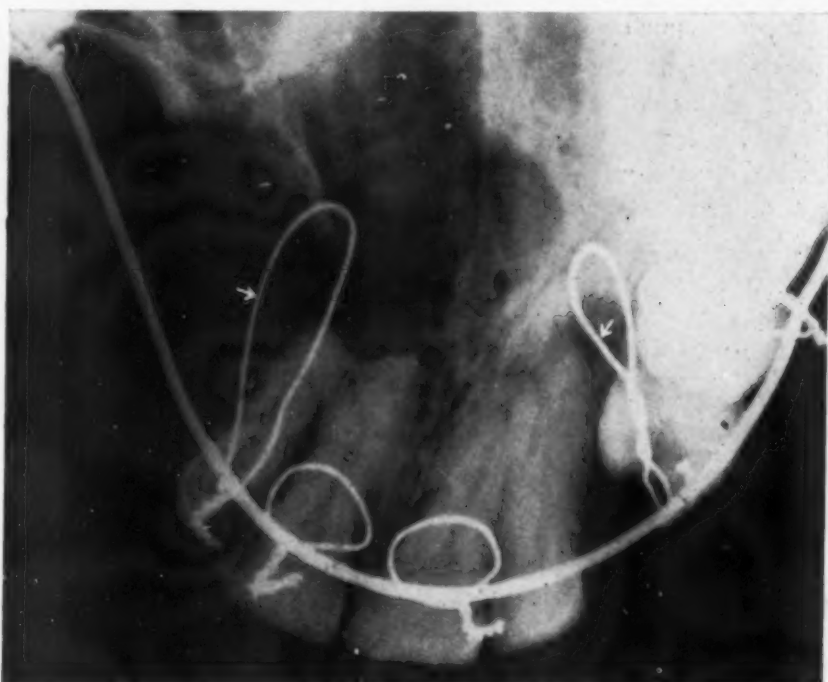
X-ray showing wires from pyriform aperture to the arch wire (arrows).
